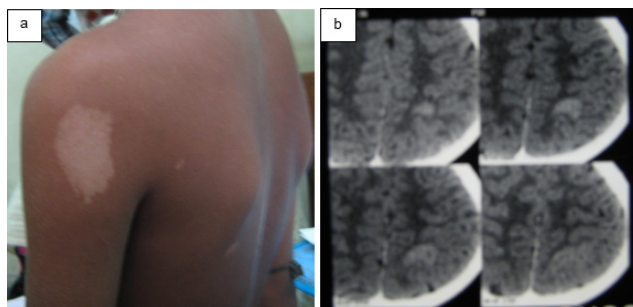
a: large >10cm Hypomelanotic patches; b: MRI: focal signal changes in high parietal regions
